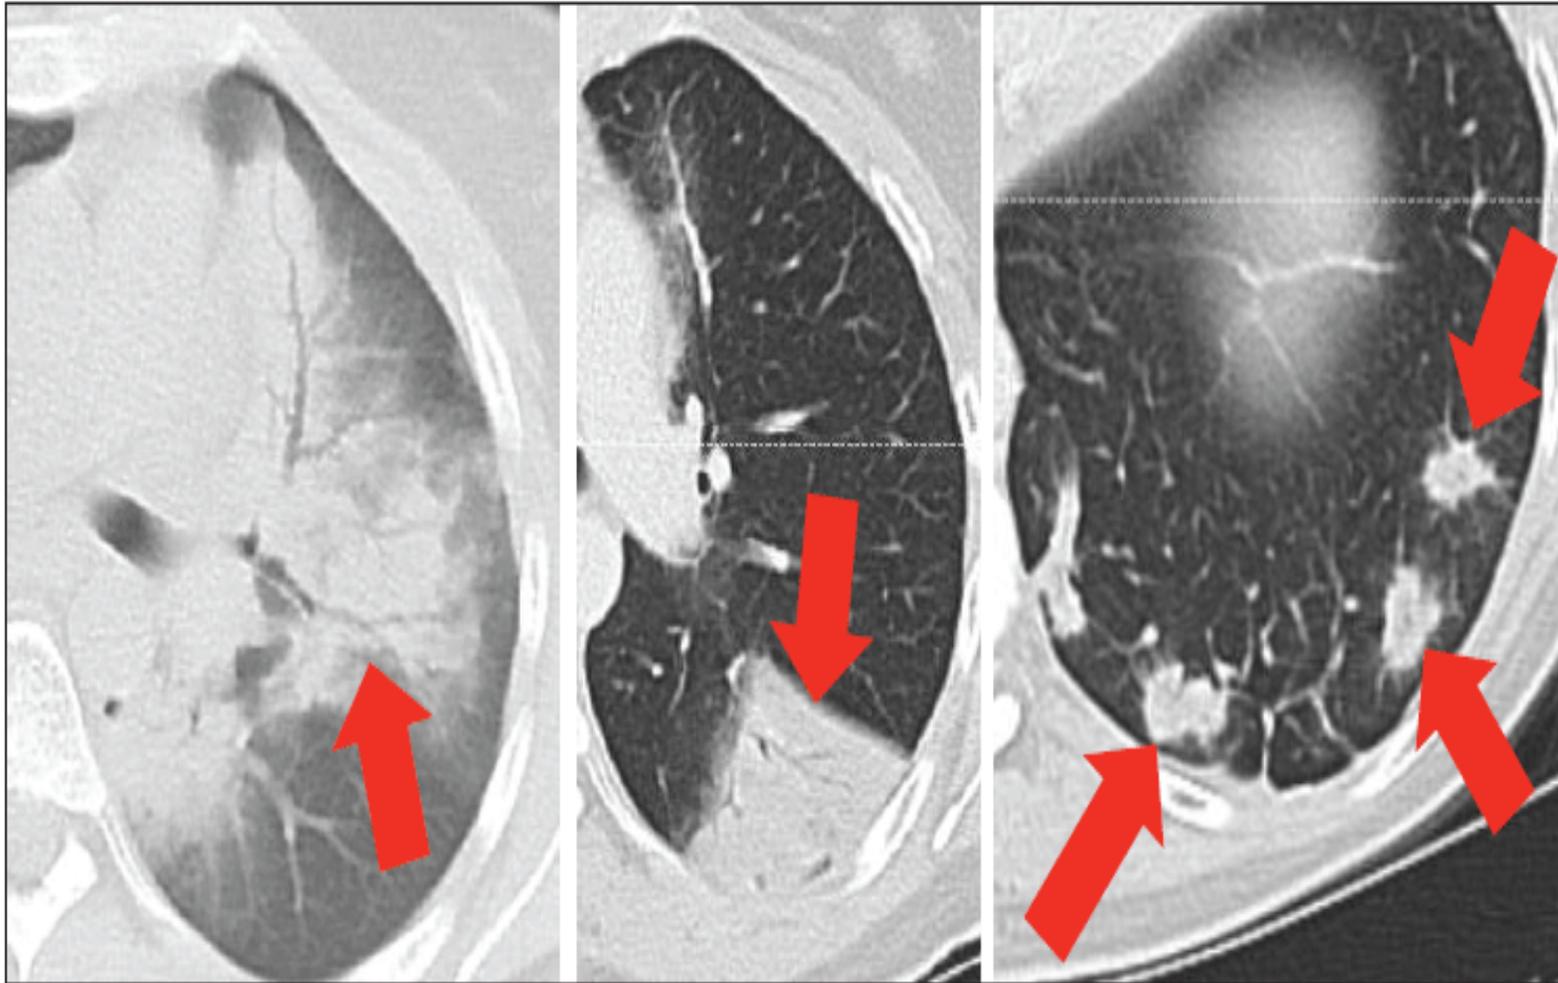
Different Radiographic Patterns of Checkpoint Blockade–Associated Pneumonitis Seen on CT Scanning in a Single Patient Treated With Ipilimumab and Nivolumab—Pneumonitis secondary to ipilimumab is shown in the left-hand panel, and pneumonitis secondary to nivolumab is shown in the center and right-hand panels. Red arrows indicate areas of radiologic abnormality.
